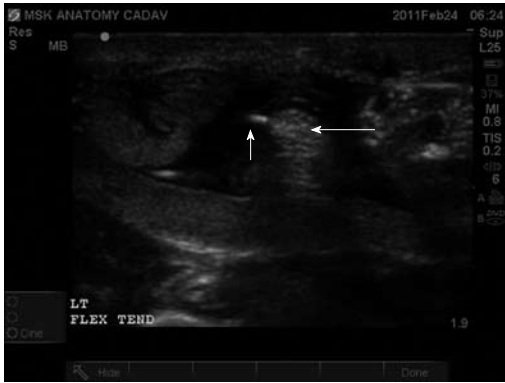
Ultrasound-guided injection of the left flexor tendon in transverse plane. Tendon injection under ultrasound (US)-guidance allows improved accuracy in tendon injection. Furthermore, US-guidance allows visualization of the fluid forming a complete peri-tendon fluid collection as noted by the hypoechoic space surrounding the heterogenous tendon appearance. Short arrow indicates the needle in transverse. Long arrow indicates flexor tendon in transverse section.
